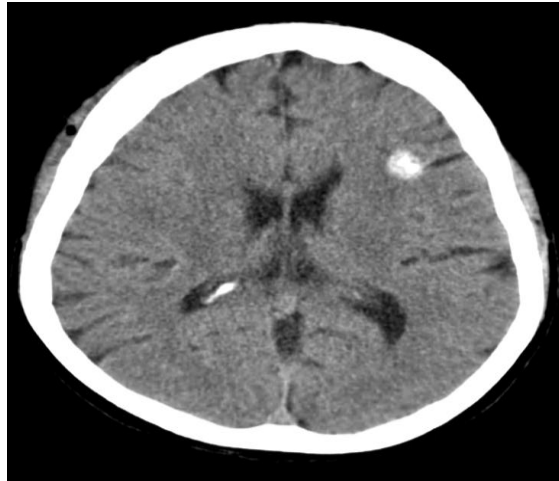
Left Frontal Lobe: Axial Non-Contrast Computed Tomography–Shows Hyperdense Nodular Lesion in the Left Frontal Lobe with Punctate Calcification (Arrow) Without.
